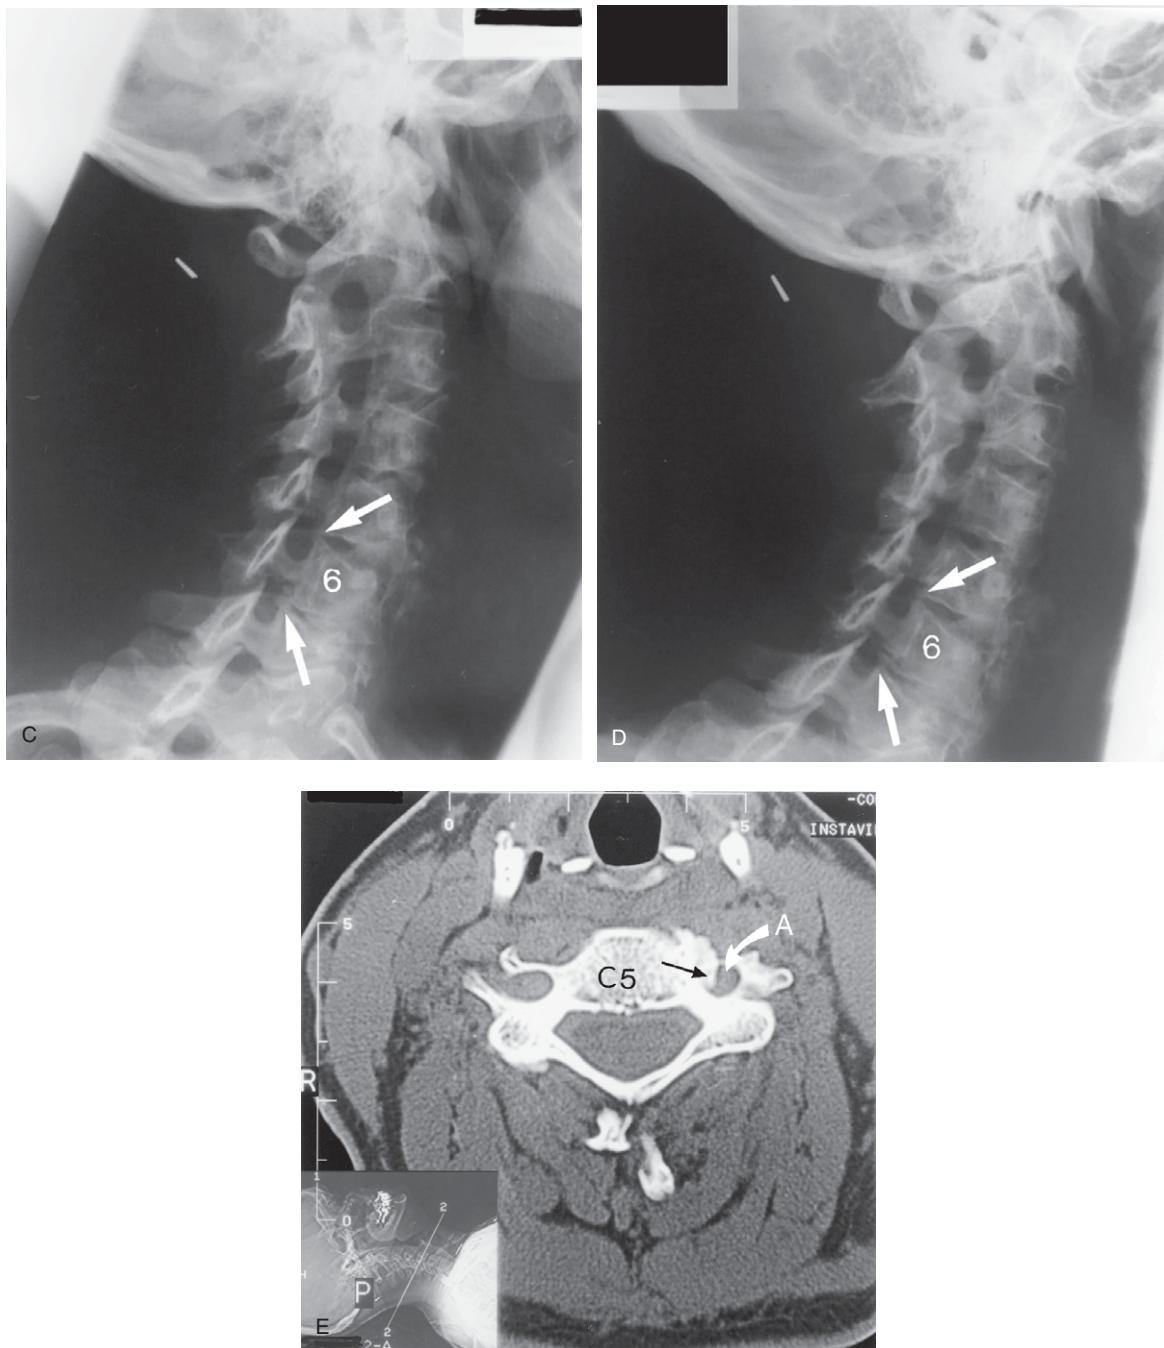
Cont'd (C,D) Cervical spine right and left oblique plain X-ray views. The white arrows indicate osteophytic hypertrophy of the uncovertebral joints at C5-6 and C6-7 although the left uncovertebral joint osteophytosis at C5-6 is best visualized on the anteroposterior radiograph (A). (E) Cervical spine CT axial image of the C5 vertebral body showing how the uncovertebral joint osteophytic encroachment (black arrow) at the medial aspect of the left C5 transverse foramen causes reduction in the calibre of the adjacent vertebral artery (A) within the transverse foramen. What cannot be seen is, of course, the effect that this osteophytic hypertrophy has on the sympathetic plexus on the vertebral artery.
